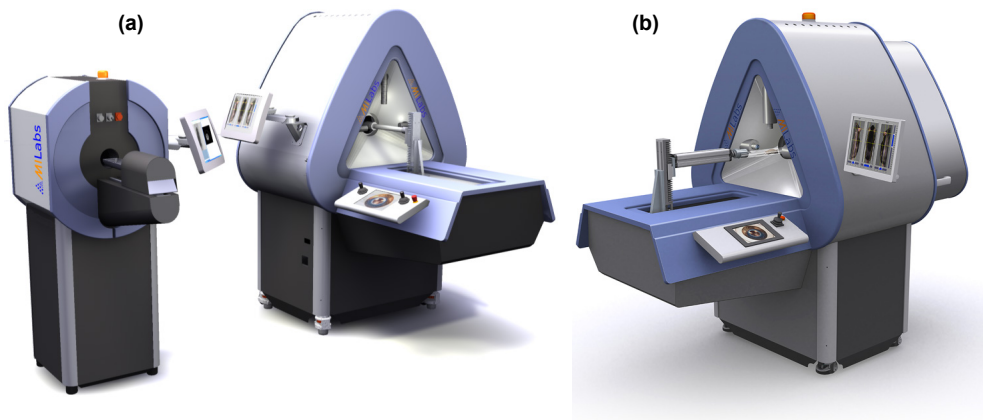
(a) Separate U-CT system and U-SPECT-II system. (b) Integrated U-SPECT-II/CT system.
